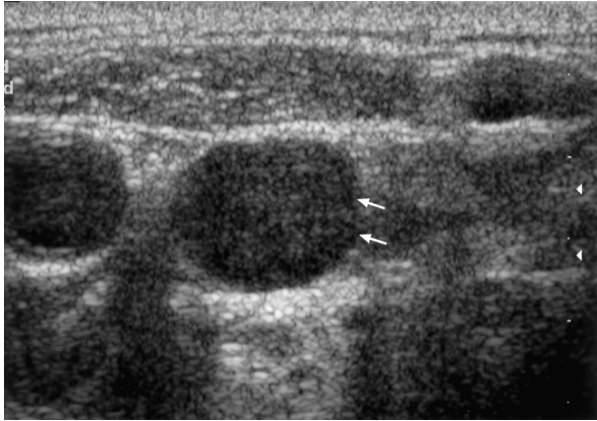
Sonogram showing a transverse scan of a round, hypoechoic metastatic node (arrows). Note the echogenic hilus is absent in the lymph node.
